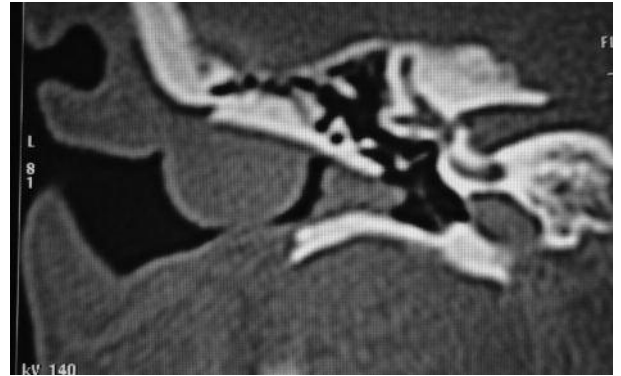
A computed tomography (CT) scan of the temporal bone found a well-circumscribed hypodense tissue, with a polypoid soft tissue aspect, located at the antero-superior part of the lateral portion of canal wall, extending from the entrance to the bone-cartilage limit of the auditory canal, with no bone erosion and no middle ear or mastoid involvement. Behind the lesion was present another hypodense tissue, probably due to wax deposit.
